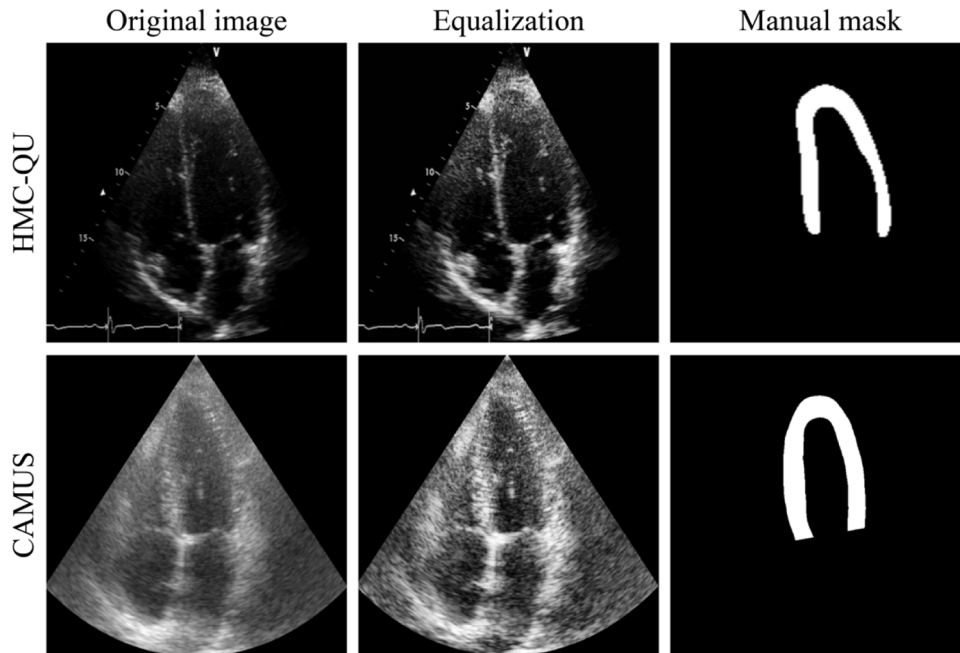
Sample frame of HMC-QU and CAMUS datasets before and after image equalization. LV wall manual mask is included for reference. Note that the HMC-QU masks appear to have a different resolution due to the varying spatial resolution of the original echocardiography recordings (ranging from 422×636 to 768×1024 pixels).
